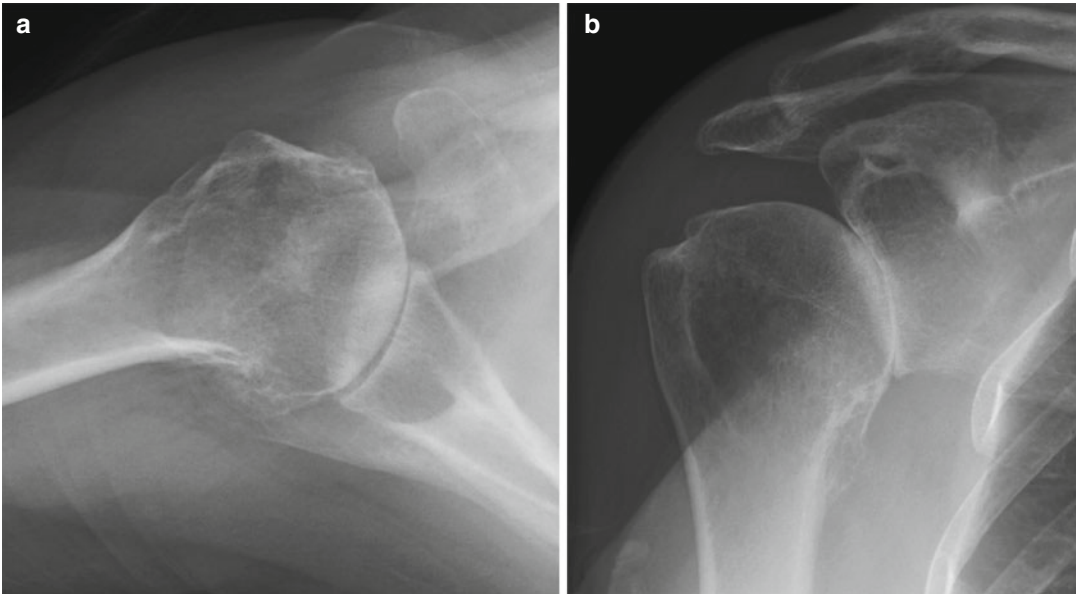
Right shoulder preoperative (a) axillary and (b) Grashey radiographs of a 60-year-old woman with primary osteoarthritis who wished to avoid the activity restrictions associated with a total shoulder replacement
